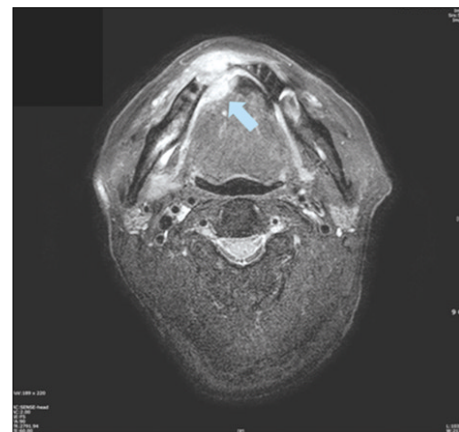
Magnetic resonance imaging of the lesion showed highly enhanced lesion in the mandible. (arrow)
